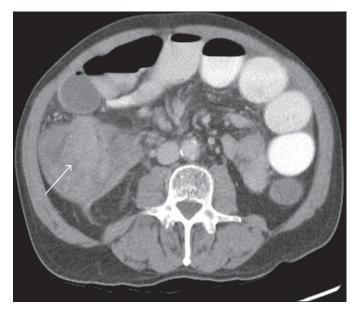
Abdominal and pelvic axial computed tomography (CT) with contrast showing the cecal mass (arrow) causing obstruction and multiple fluid-filled small bowel loops.
